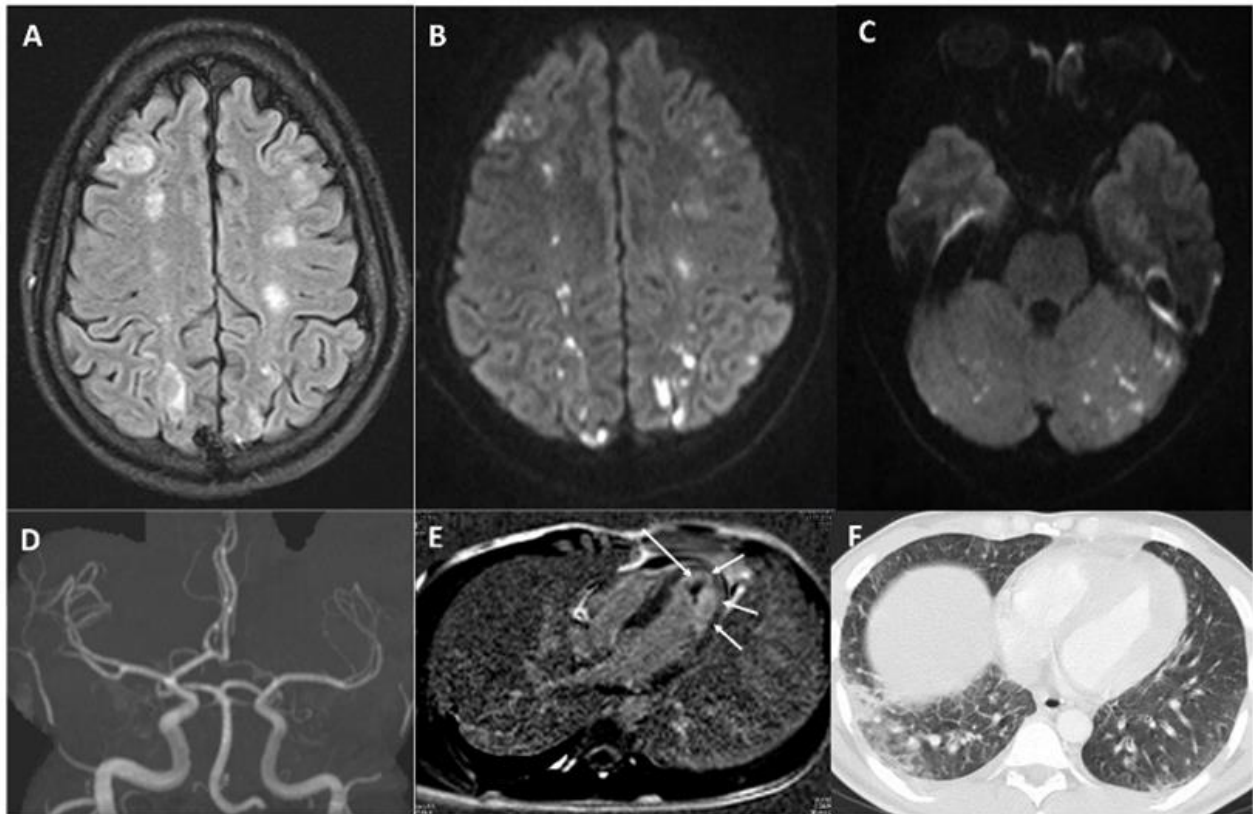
Axial FLAIR (A) and diffusion-weighted (B,C) images show multiple, small infarcts in all vascular border-zone territories. MR angiography (D) displays no abnormality. Cardiac MR imaging (E) shows single left ventricular apical thrombus (long arrow) and endomyocardial fibrosis (short arrows). Thoracic CT (F) shows changes compatible with interstitial lung disease.
